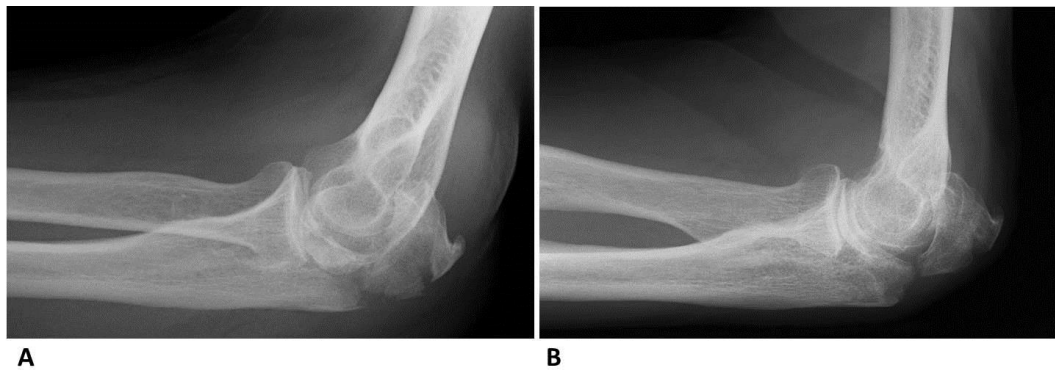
A) A lateral radiograph of the left elbow demonstrating an isolated displaced fracture of the olecranon in an 86-year-old man who was managed non-operatively with a collar and cuff. B) Radiographs taken at six months following injury. At 3-year follow-up the patient was asymptomatic with an excellent outcome according to the DASH and Oxford Elbow Score.
